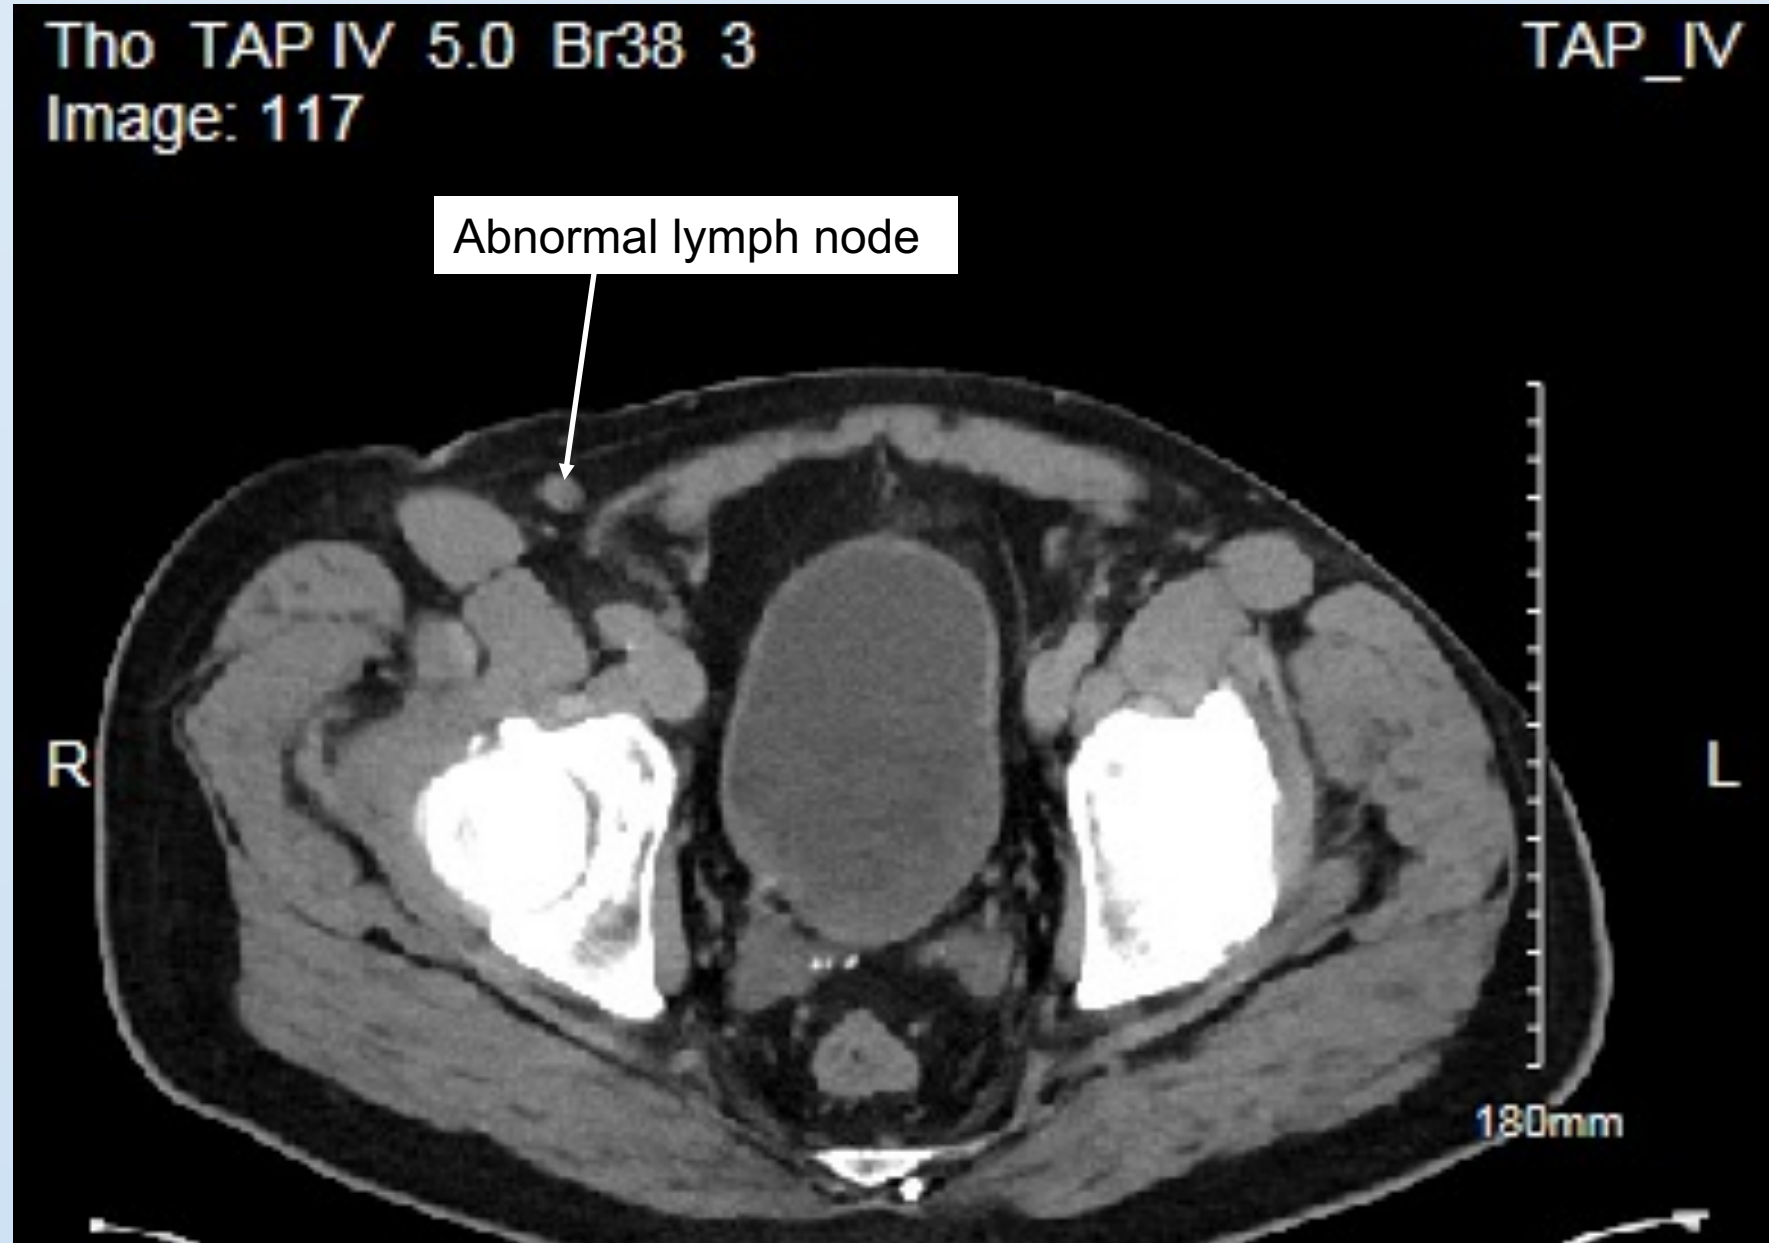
Axial image of a CT TAP with contrast which detected also the suspicious right inguinal lymph node
